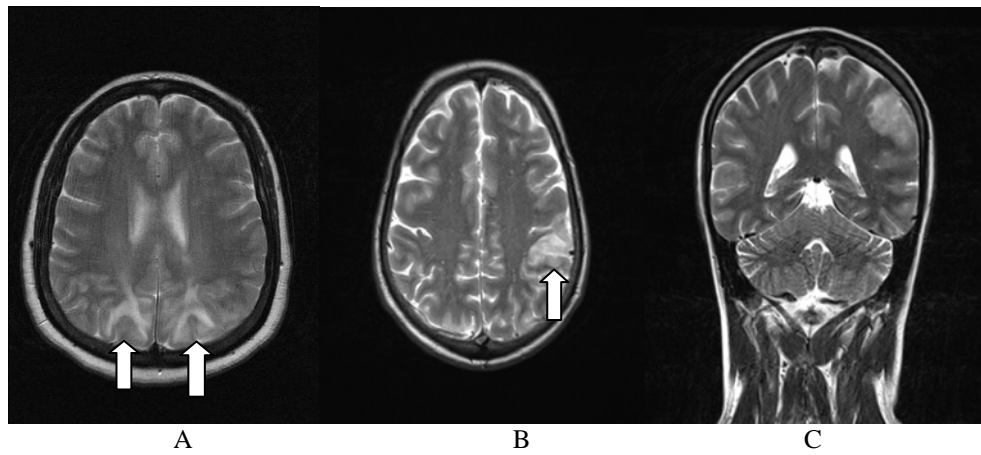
Axial (A& B) and coronal T2 MRI images showing hyperintense signal in cortical and subcortical regions of parietal and occipital lobes representing vasogenic edema. Note the asymmetry in B& C.
